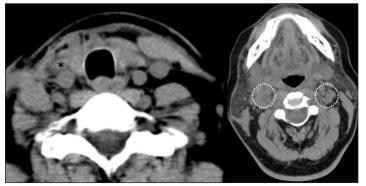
Contrast-enhanced CT scan of the neck. Enhancing hypodense mass in the right thyroid lobe (black asterisk) and multiple enlarged right cervical lymphadenopathies (*white dashed circles*)
